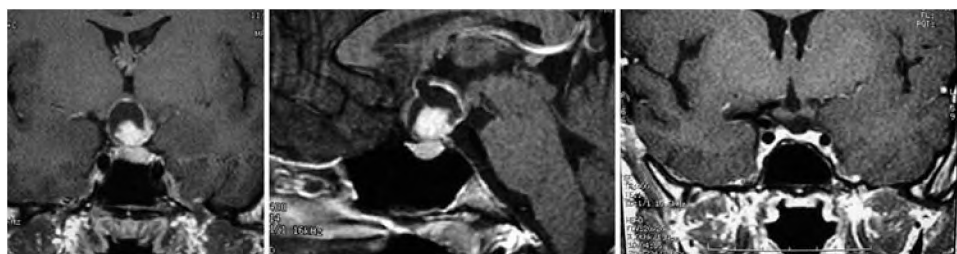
Coronal (left) and axial (center) T₁-weighted postcontrast MR images obtained preoperatively, demonstrating a suprasellar craniopharyngioma with nodular and cystic portions. The tumor was approached via an extended transsphenoidal route. A coronal MR image (right) obtained 4 years after surgery, revealing complete resection.
